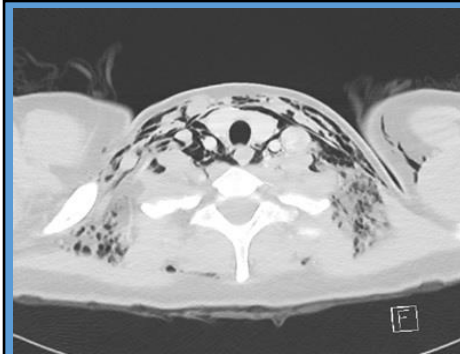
CT demonstrating extensive subcutaneous emphysema
